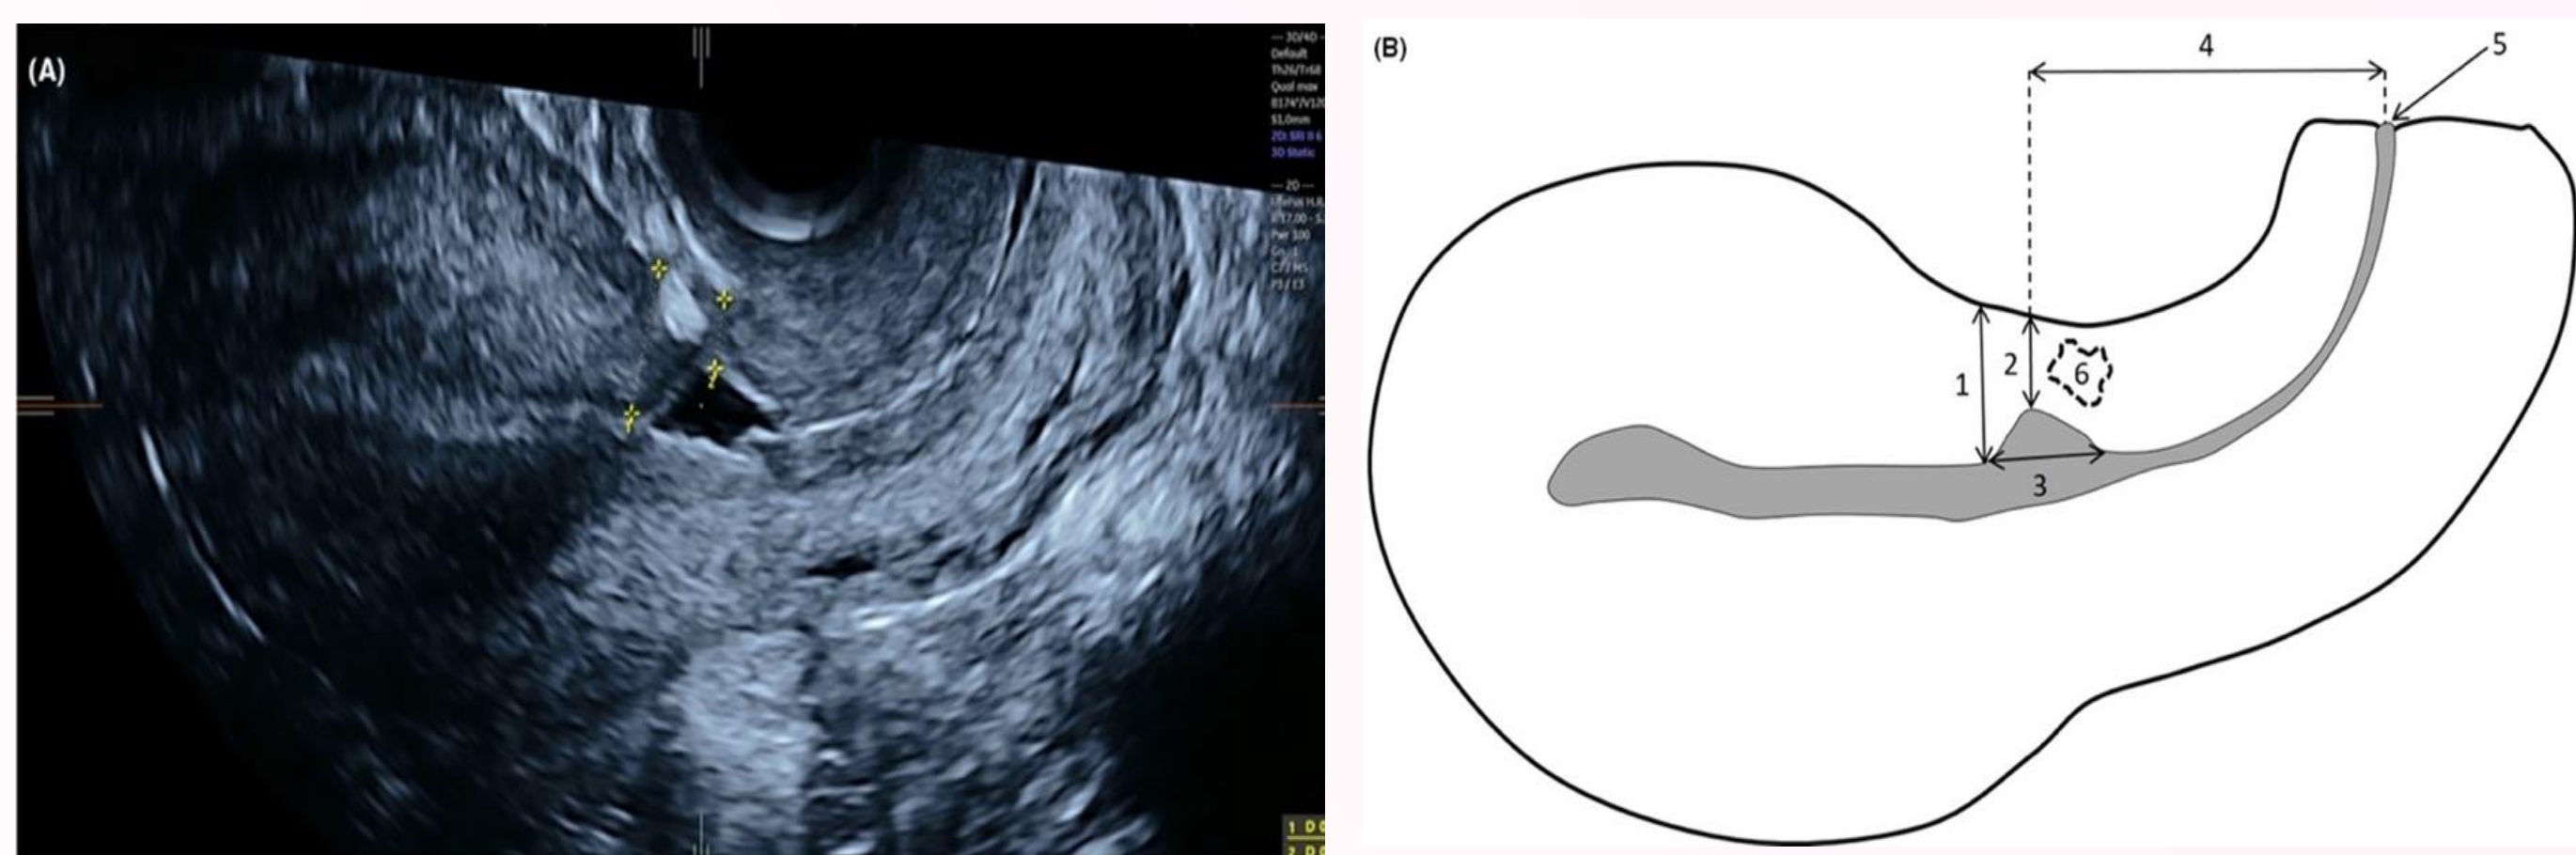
A suggested guide of how to scan and report Gynaecology scans and CSDs, Based on the review of the current literature and Savukyne et al, 2021. 'Transvaginal Sonographic Evaluation of Caesarean Section Scar Niche in Pregnancy: A Prospective Longitudinal Study.'
